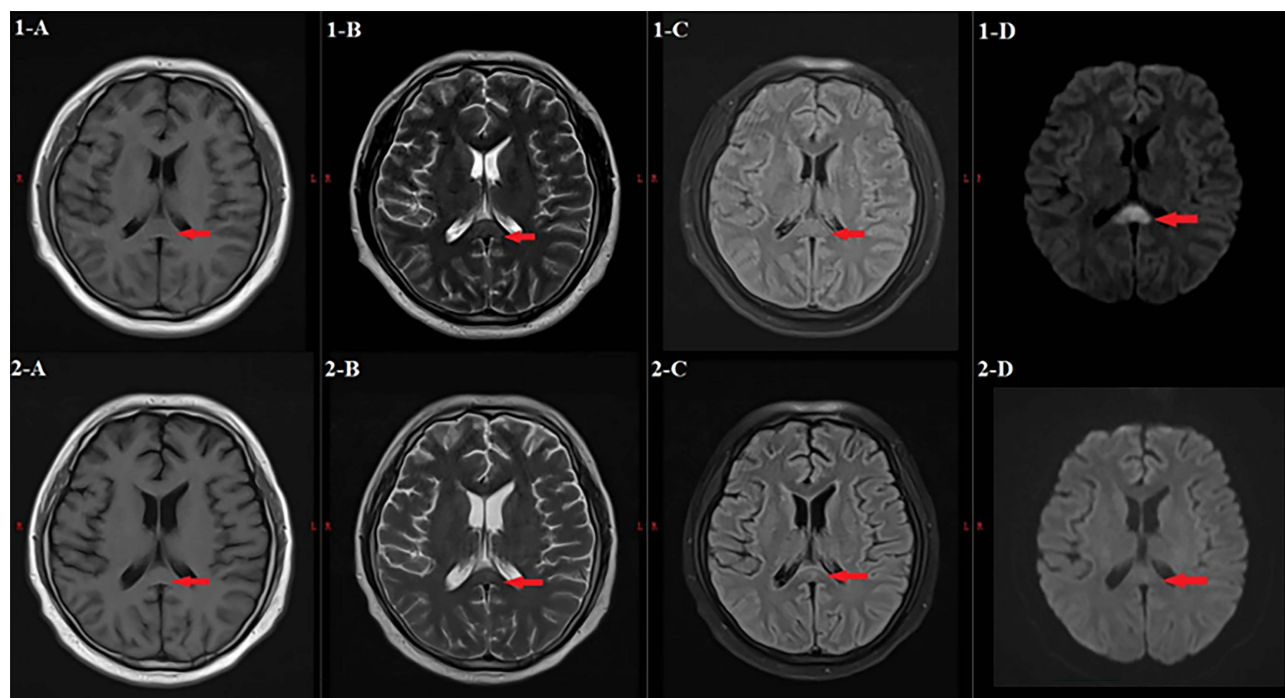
Patient 2: 1- MRI of the patient's head on February 16, 2023. 1-A, patchy slightly longer signals were observed in the splenium of the corpus callosum at T1; 1-B, a slightly longer T2 was observed; 1-C, FLAIR, showed hyperintensity; 1-D, high signal on the DWI sequence. 2- Repeat MRI on March 22, 2023. 2-A, T1; 2-B, T2; 2-C, FLAIR; 2-D, DWI; the abnormal signal range in the splenium of the corpus callosum was reduced. (The red arrow in the pictures denotes the abnormal signals of the splenium of the corpus callosum.).
